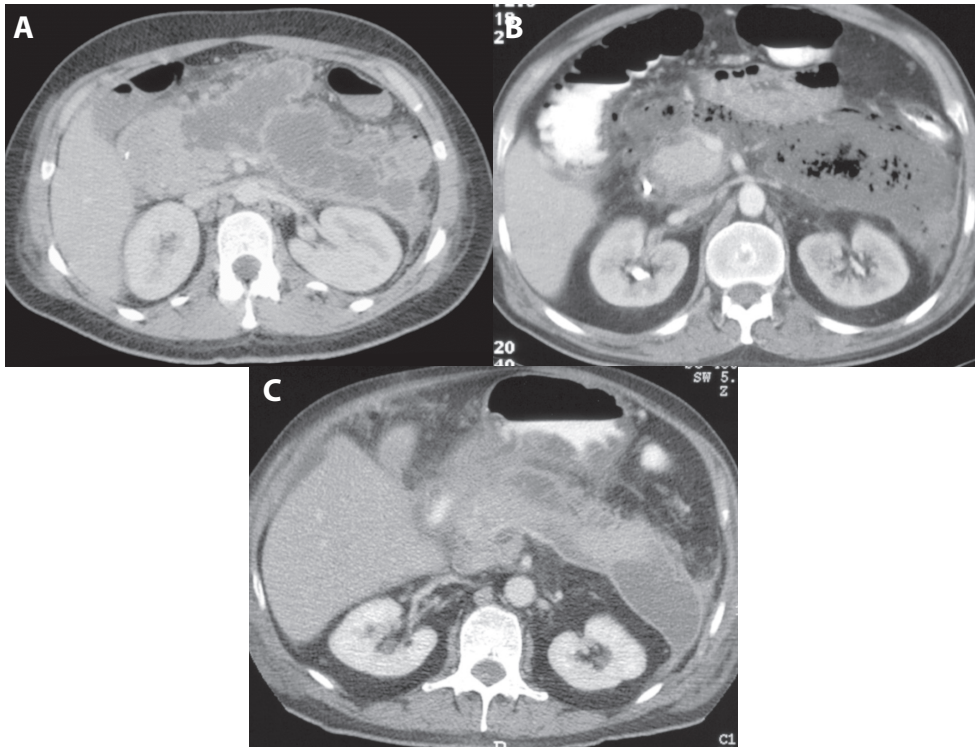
The use of the Atlanta Classification on CT in necrotizing pancreatitis. A, Computed tomography scan 12 days after onset of disease. The definitions chosen for this collection were “pseudocyst” (n = 1), “pancreatic abscess” (n = 1), “pancreatic necrosis” (n = 1), and “mixture” (n = 2). B, Computed tomography scan 27 days after onset of disease. The definitions chosen for this collection were “pancreatic abscess” (n = 3) and “mixture” (n = 2). C, Computed tomography scan 31 days after onset of disease. The definitions chosen were “pancreatic necrosis” (n = 1), “pancreatic abscess” (n = 1), “pseudocyst” (n = 1), and “mixture” (n = 2).
